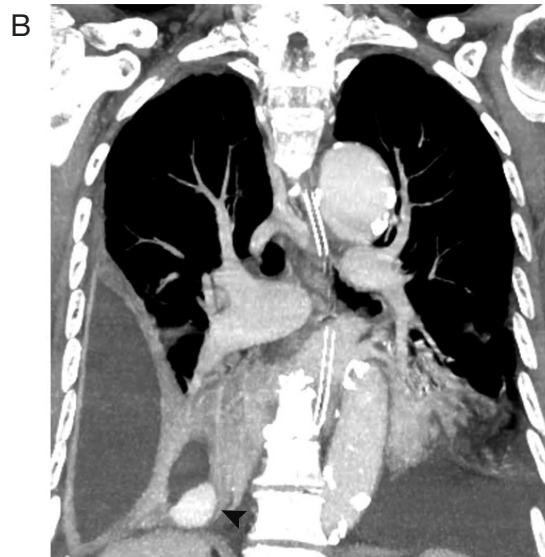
Enhanced computed tomography image (CT) on the 29th hospital day shows a highly enhanced mass existing inside the abscess in the right lower lobe (A). Coronal reformatted images (B) demonstrate an enhanced mass (arrowhead) in the lung abscess, which was revealed to be fed by the pulmonary artery on volume-rendering CT angiography (C; arrow).
